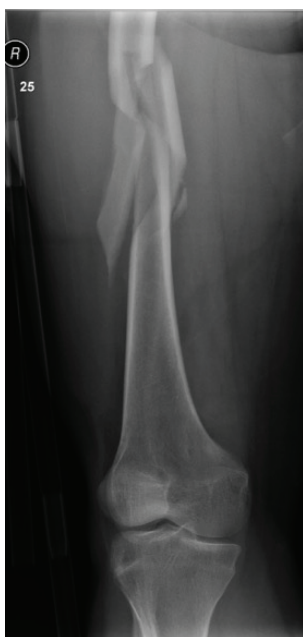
Anteroposterior (AP) and Lateral radiograph of femoral fracture in the patient demonstrating a comminuted mid-diaphyseal spiral femoral fracture.
